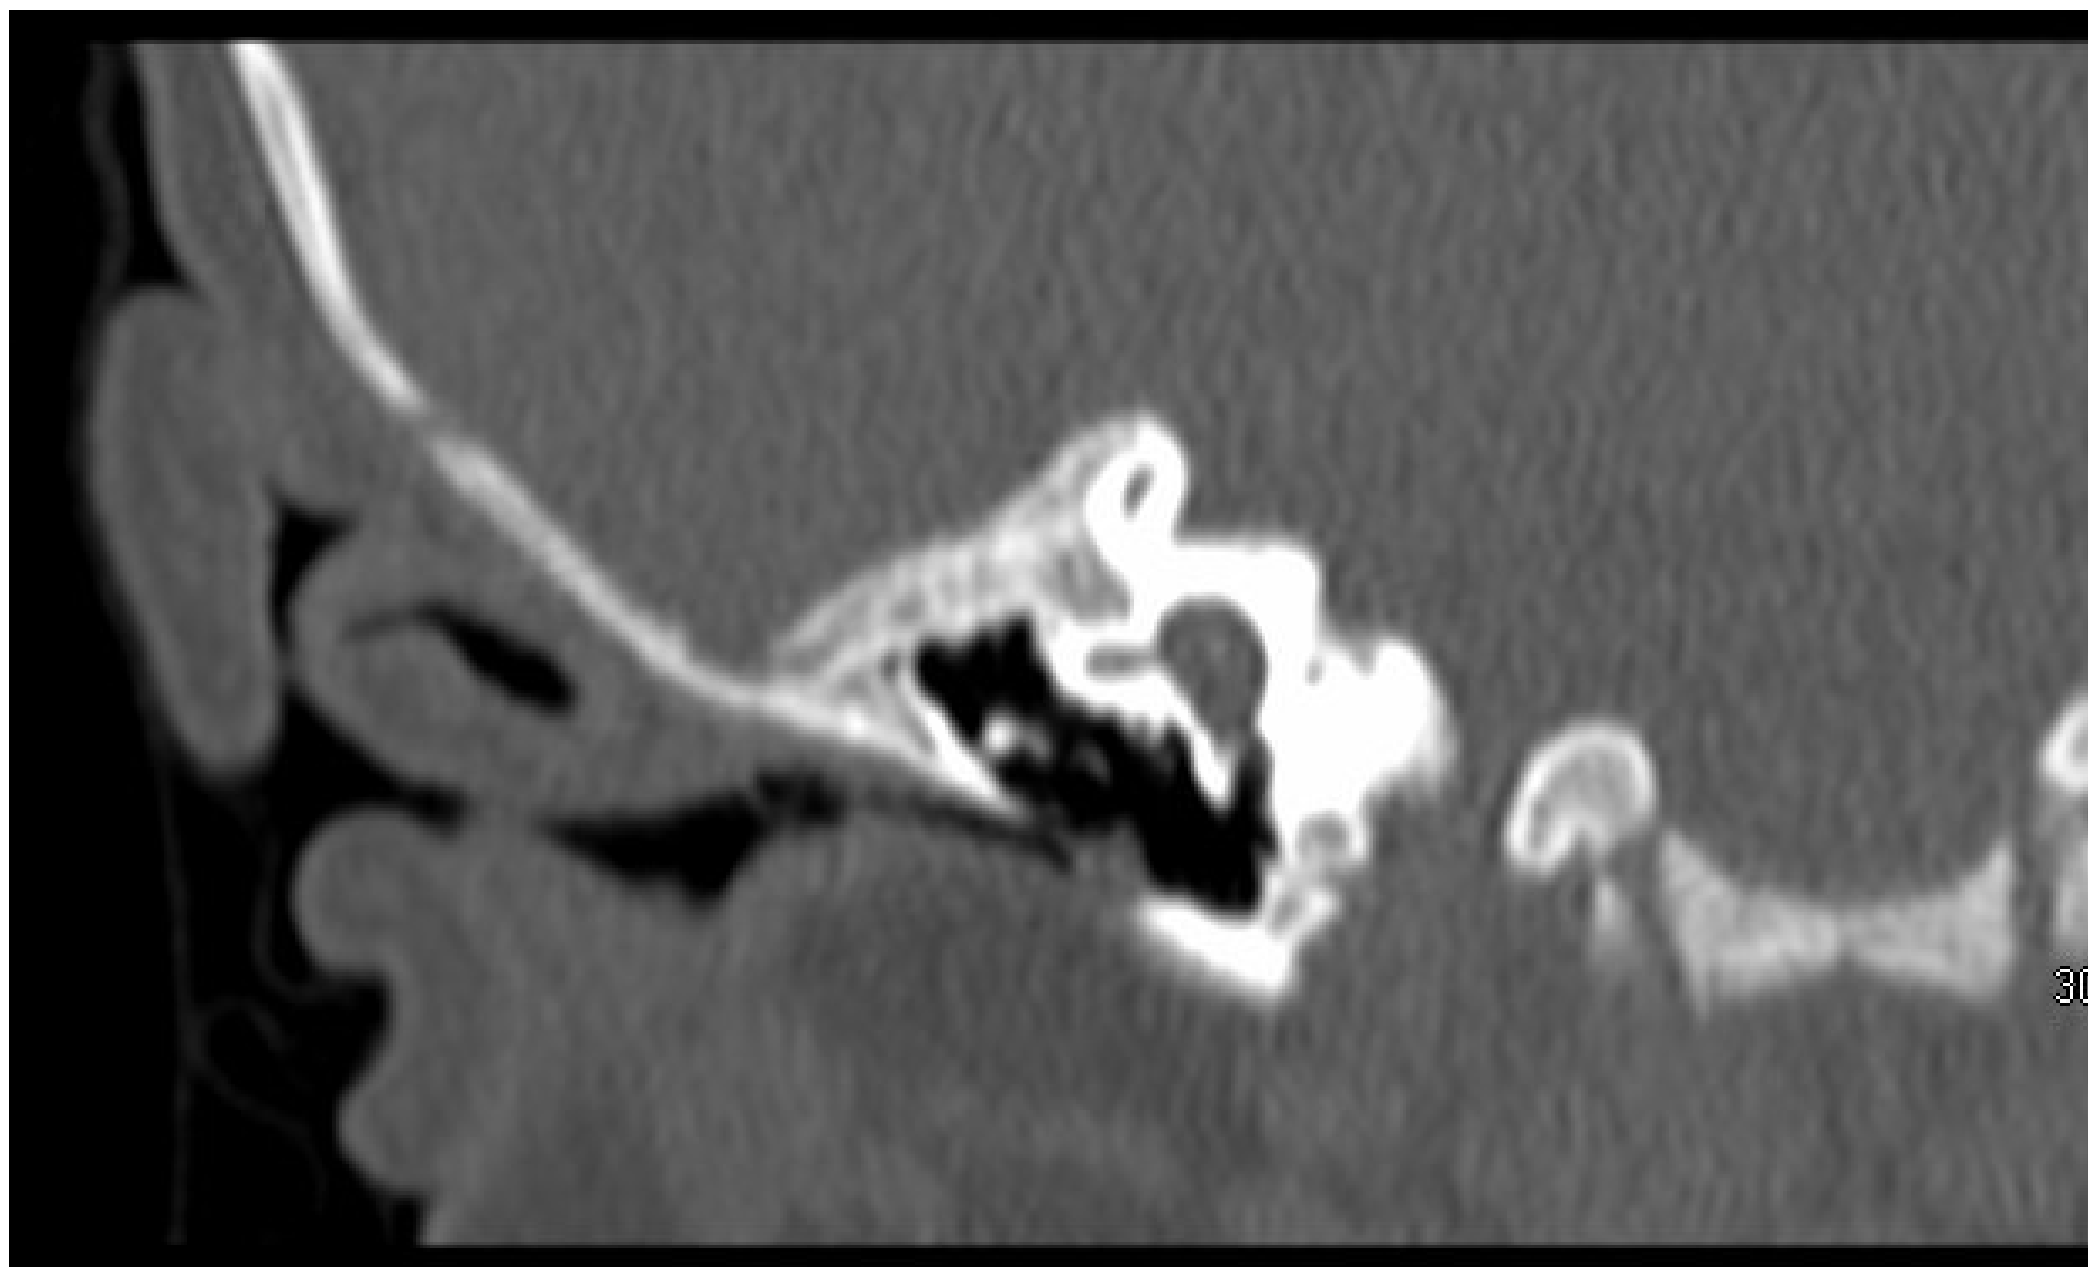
Coronal CT scan in the bone window of the right temporal bone demonstrating low lying tegmen typani and tegmen mastoideum.
